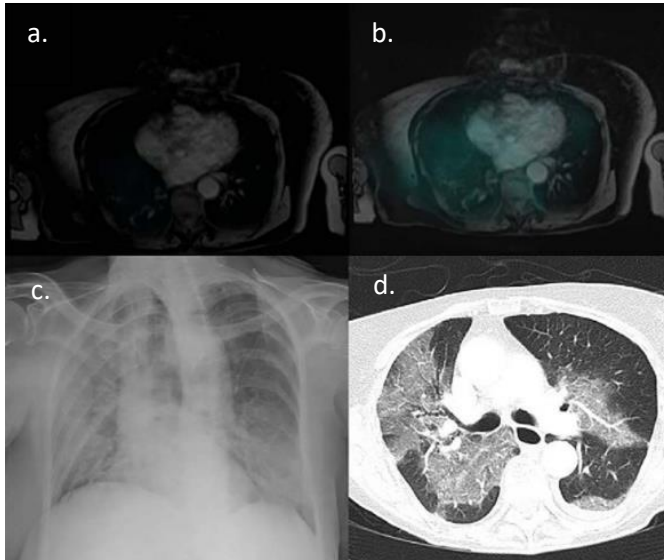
Radiation pneumonitis. Superselective SIRT was indicated in a patient with HCC who had a 27% LS fraction based on pretreatment ^{99m}Tc -MAA scan (a). A dose of 0.5 GBq of resin microspheres was prescribed, which should have resulted in an estimated dose of radiation to the lungs of 7 Gy. A higher exposure was suspected based on the post-SIRT Brehmsstrahlung-SPECT images (b). Cough, dyspnea, and hypoxemia developed 22 days after SIRT. Chest X-ray (c) and CT scan (d) showed the typical pattern of radiation pneumonitis, which was fatal in this case. From Sangro *et al.* [41]
